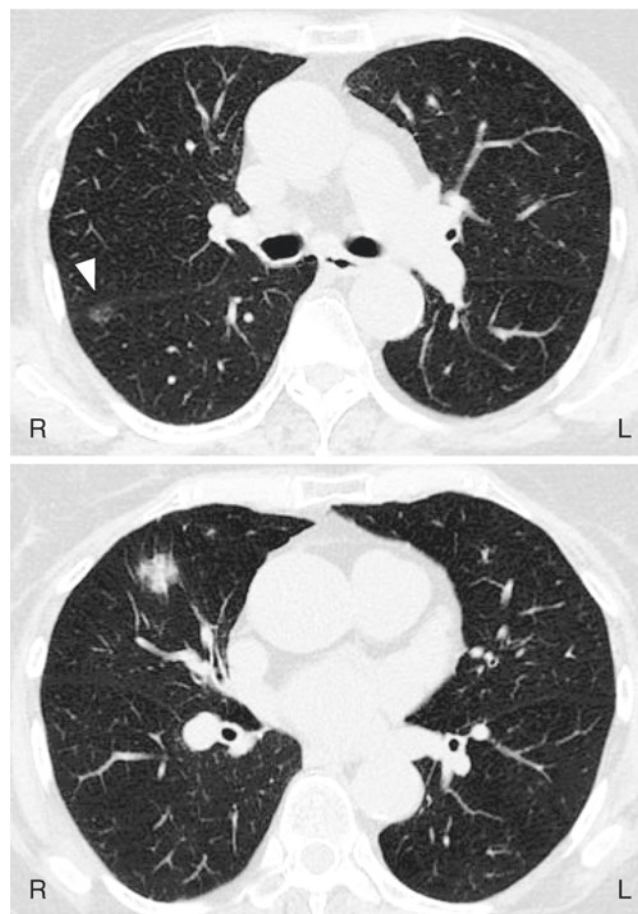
Axial cuts from high-resolution CT scan showing a subtle ground-glass opacity nodule (GGO) in the right lower lobe (arrowhead, top panel) and spiculated 22 x 19 mm right middle lobe opacity (bottom panel)
